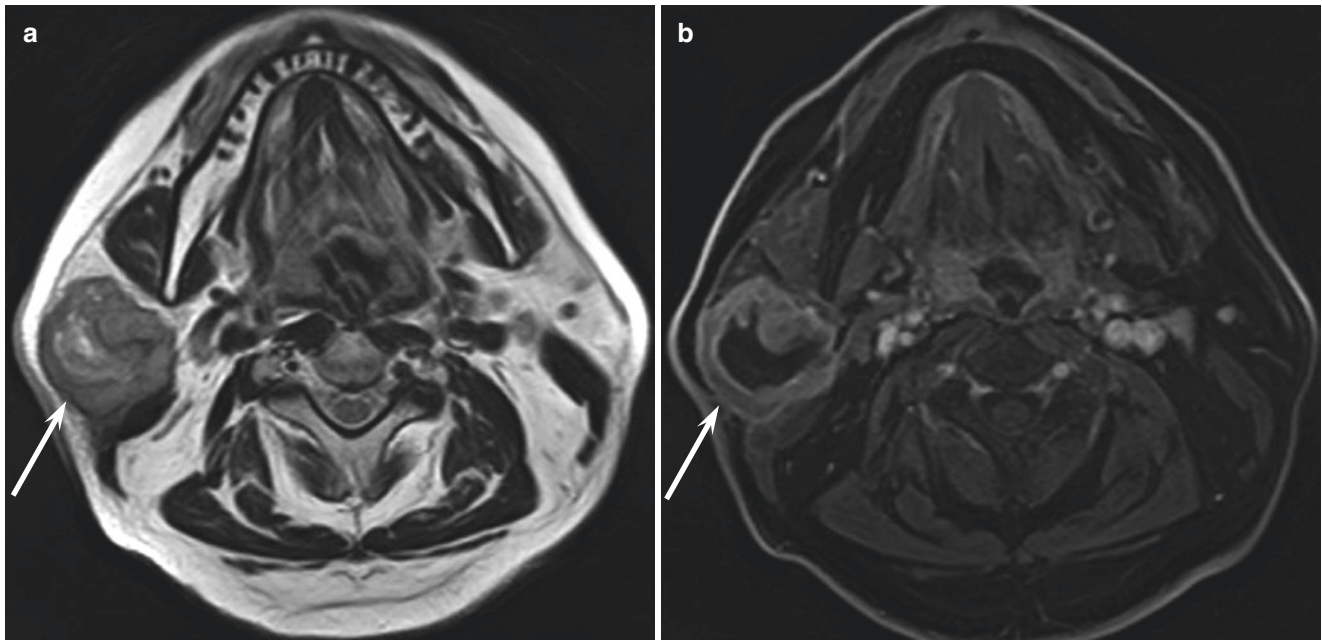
A 62-year-old man with salivary duct carcinoma of the right parotid gland. (a) T2-weighted image shows an ill-defined, heterogeneously iso- to hyperintense lesion (arrow). (b) Fat-suppressed
